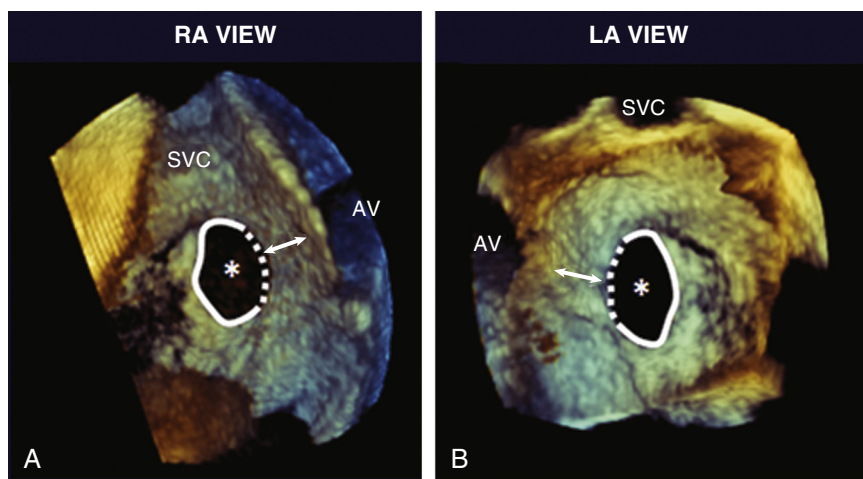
Assessment of ASD rims with 3D TEE in A, right atrial (RA) and B, left atrial (LA) views. The anterior rim is represented as the distance between the dotted line and the aorta (arrow). Asterisk, secundum ASD. AV, Aortic valve. (From Saric M, et al. Imaging atrial septal defects by real-time three-dimensional transesophageal echocardiography: step-by-step approach. *J Am Soc Echocardiogr*. 2010;23:1128.)
